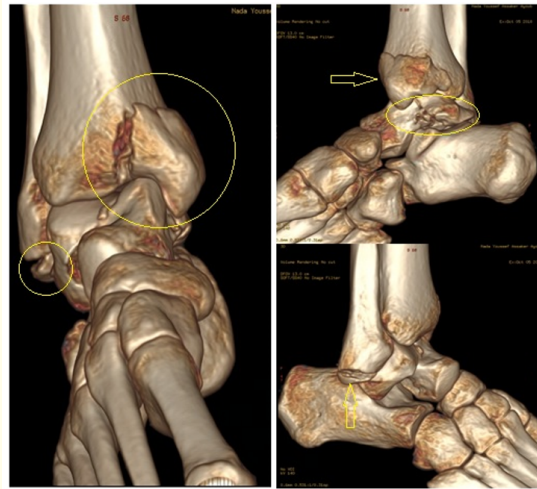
3D reconstruction CT scan of the Right ankle showing bimalleolar fractures with comminuted talar body and neck fractures.
